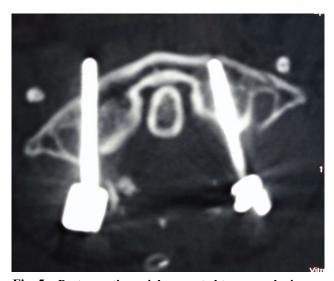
Postoperative axial computed tomography image demonstrating a good position of screws in the C1 lateral masses and complete reduction of the C1-C2 subluxation.
